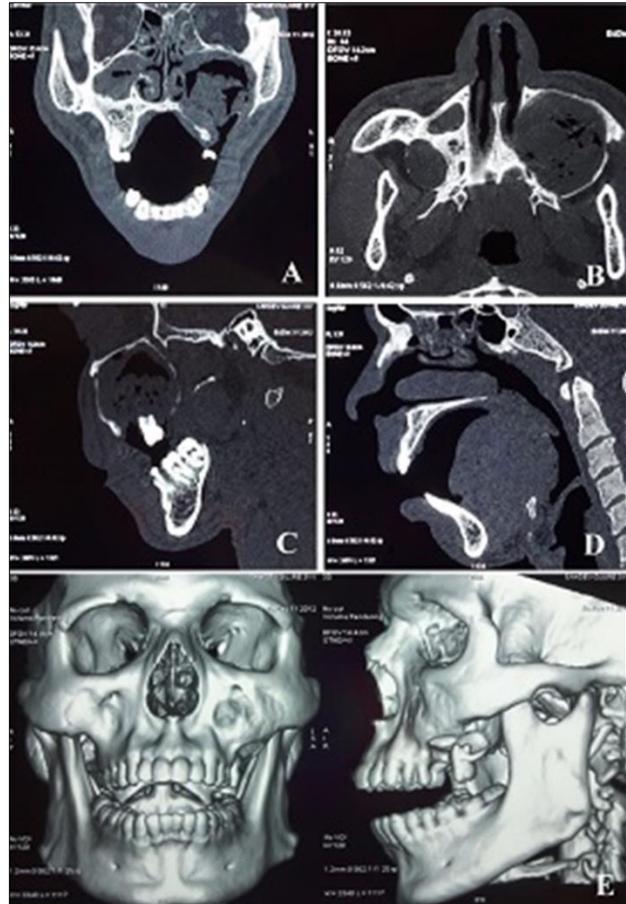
(A, B, C) CT sections (coronal, axial and sagittal) depict a well-defined expansile, cystic lesion measuring approximately 4.6 x 3.8 x 4.5 cms, involving the left maxillary sinus region. Thinning and erosion of the medial, postero-lateral and infero-lateral bony wall along with prominent erosion of alveolus process of maxilla was evident. An irregular soft tissue shadow was seen, occupying the walls and the lumen of the cystic cavity with multiple air pockets, along with the obliterated osteomeatal complex on the left side. Involvement of ethmoidal sinus was also evident due to mucosal thickening; (D) CT section (sagittal) depicts the involvement of sphenoidal sinus; (E) 3D reconstruction depicting the destruction of the left alveolus process of maxilla in the posterior region along with the expansion of cortex.
